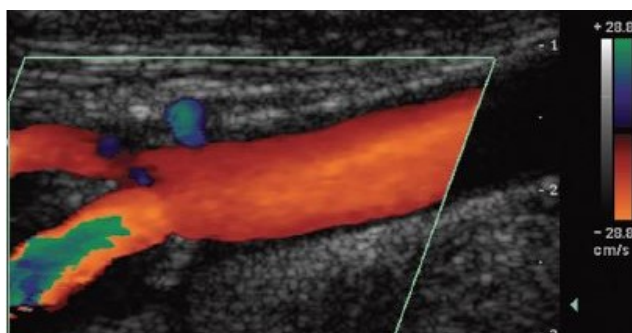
Color Doppler image of common carotid flow with a blue-red scale, in which the colors represent the direction of the blood flow. Adapted from [10].
